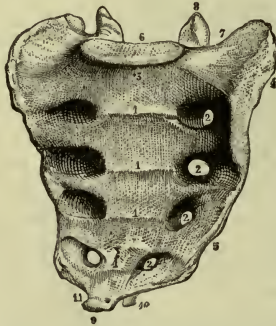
SACRUM, ANTERIOR ASPECT.
